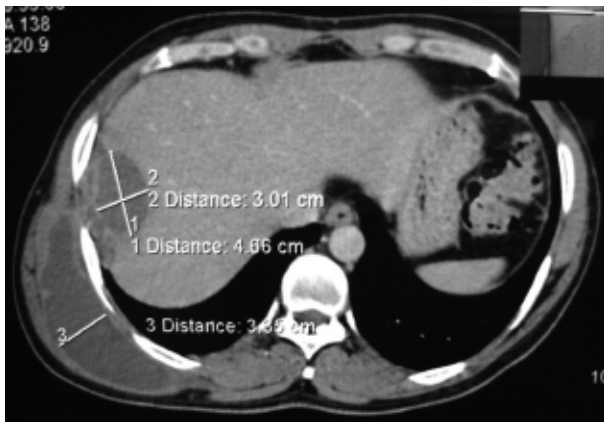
Contrast enhanced CT of the thorax showing a solitary right lobe liver abscess tracking into the inter muscular plane in the posterior chest wall
